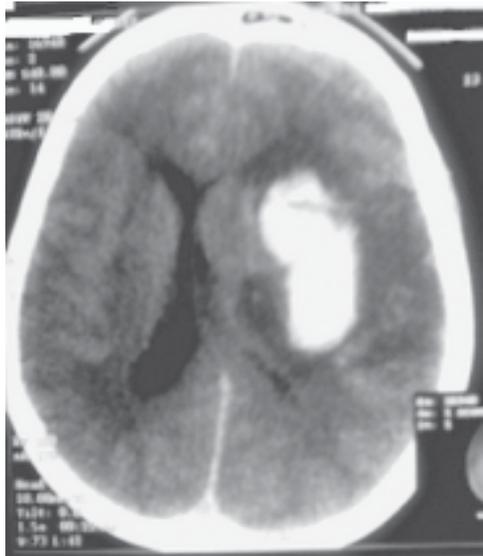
Plain CT scan showing left basal ganglion ICH with midline shift and perilesional oedema.
